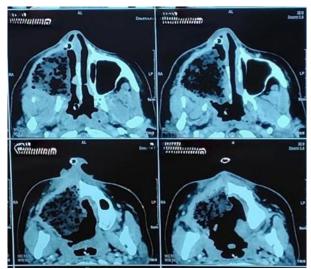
Axial section of the postoperative facial CT scan
